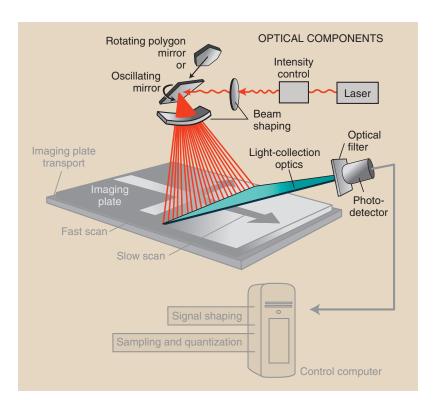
The optical components and optical path of a computed radiography (CR) reader are highlighted.
